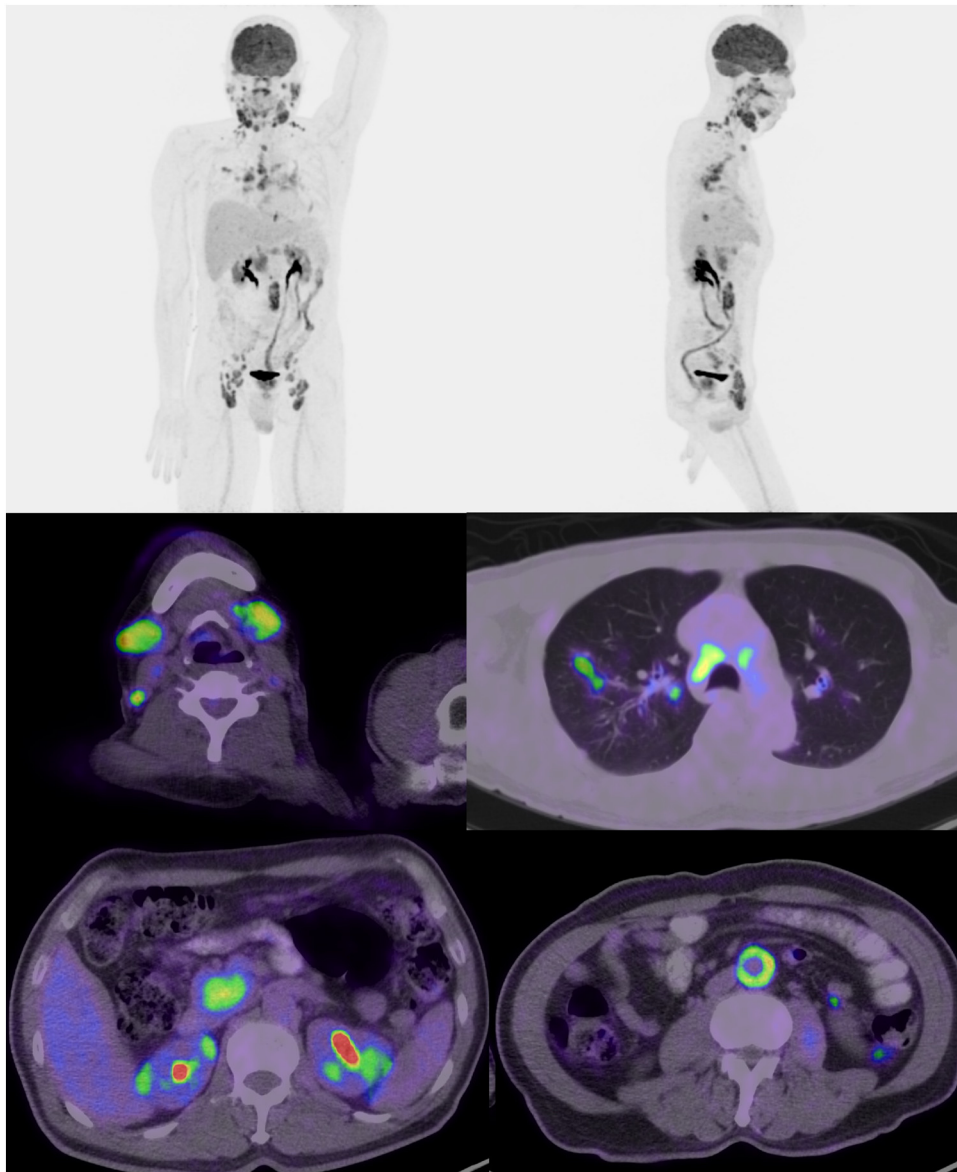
FDG PET/CT: FDG PET/CT maximum intensity projection (upper row) and fused trans-axial images (lower row) showing multiple lymph nodal involvement, lacrimal/salivary gland uptake, a right pulmonary focus, a hypermetabolic pancreatic head lesion, renal cortical lesions, and intense circumferential uptake in the abdominal aorta.
